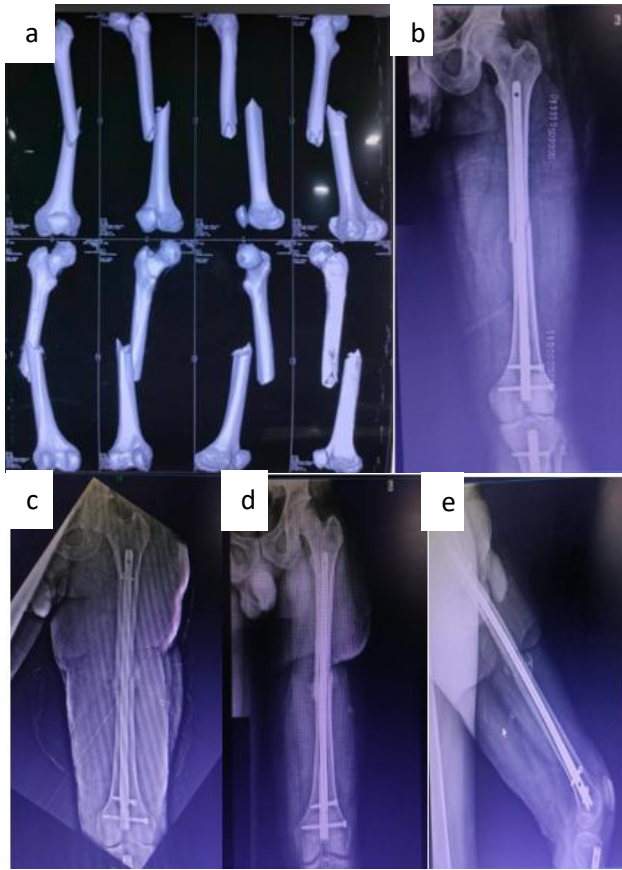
Pre & post operative images. (a) Pre-Op CT, (b) immediate post-op, (c) at 6 weeks, (d) at 3 months and (e) at 6 months.
